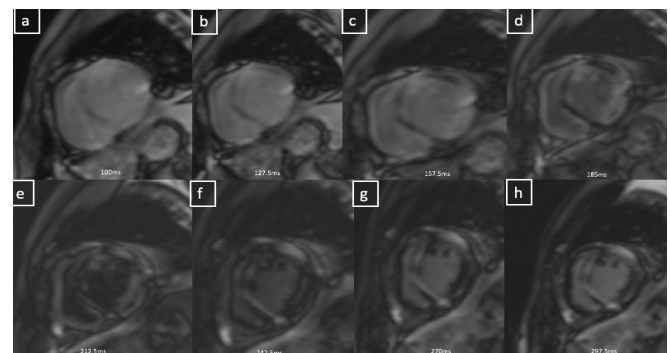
The image presents the cardiac magnetic resonance imaging short-axis view of the inversion-time scout assessment (TI scout), taken 7 minutes after the administration of gadolinium-based contrast material at increasing inversion times (A-F). The images reveal inhomogeneous nulling of the left ventricular myocardium, with certain areas of the myocardium demonstrating nulling (C) occurring before that of the blood pool (E).
